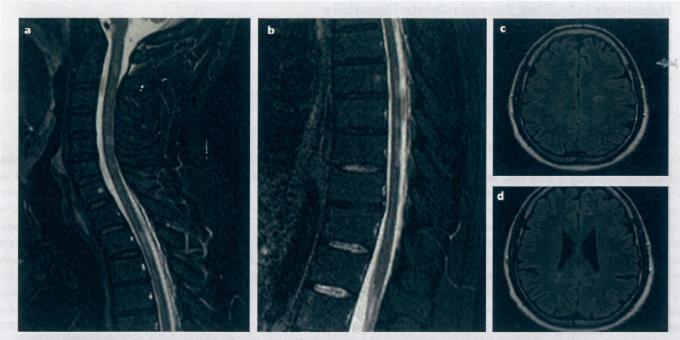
Spinal cord MRI showing cervical (a) and dorsal (b) demyelinating lesions and brain MRI showing lesions compatible with demyelinating/inflammatory disease (c, d)
